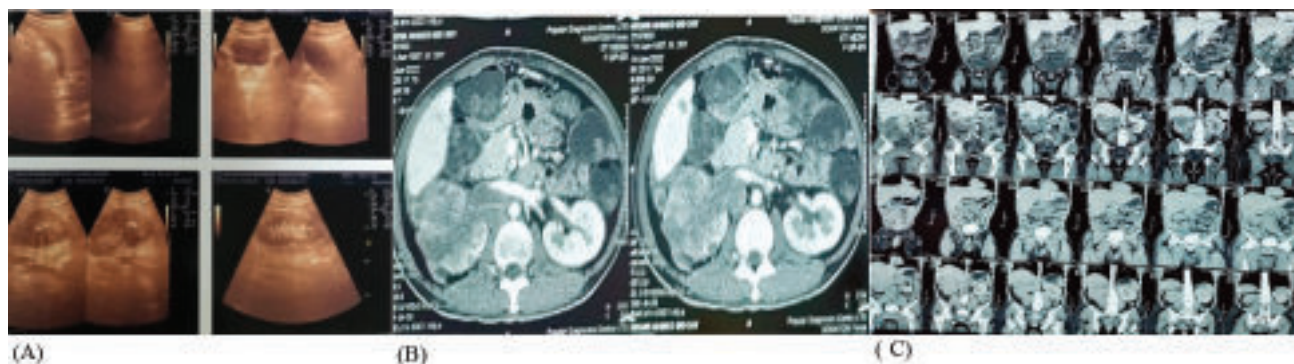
(A) USG W/A showing enlarged right kidney, (B), (C) CT scan of the whole abdomen showed inhomogeneous mixed density diffuse lesion (11cm x 6cm) seen predominantly in the calyceal system in right kidney with cortical and perinephric invasion and mild contrast enhancement of the lesion seen and the lesion extending into the right renal vein and adjacent IVC. The liver showed a lobulated hypodense lesion (4.5cm) in right lobe segment VI suggesting a metastatic lesion.
